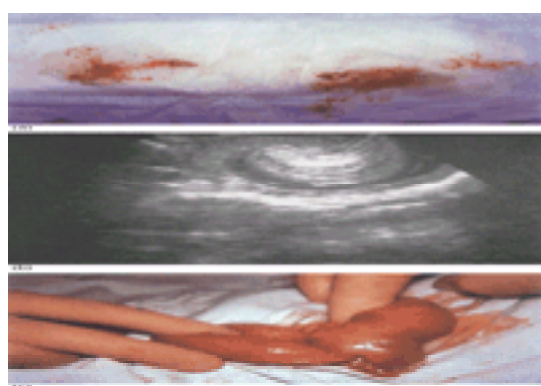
(a) Intussusception: redcurrant jelly stool. (b) Ultrasound of intussusception to show 'doughnut' appearance (c) Intussusception: terminal ileum intussuscepted within the caecum at laparotomy.
